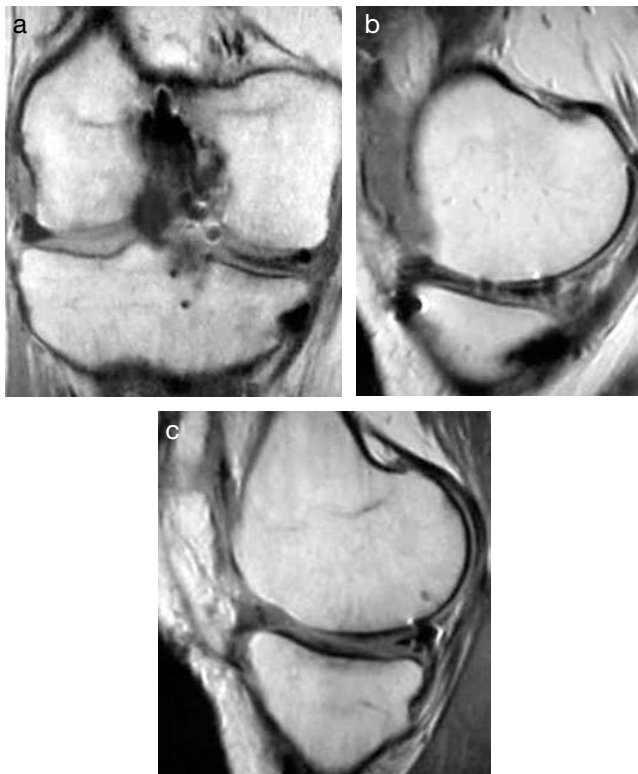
MRI of collagen meniscal implants. a y b: thinning can be seen in the sutured area. c: implant breakage.
